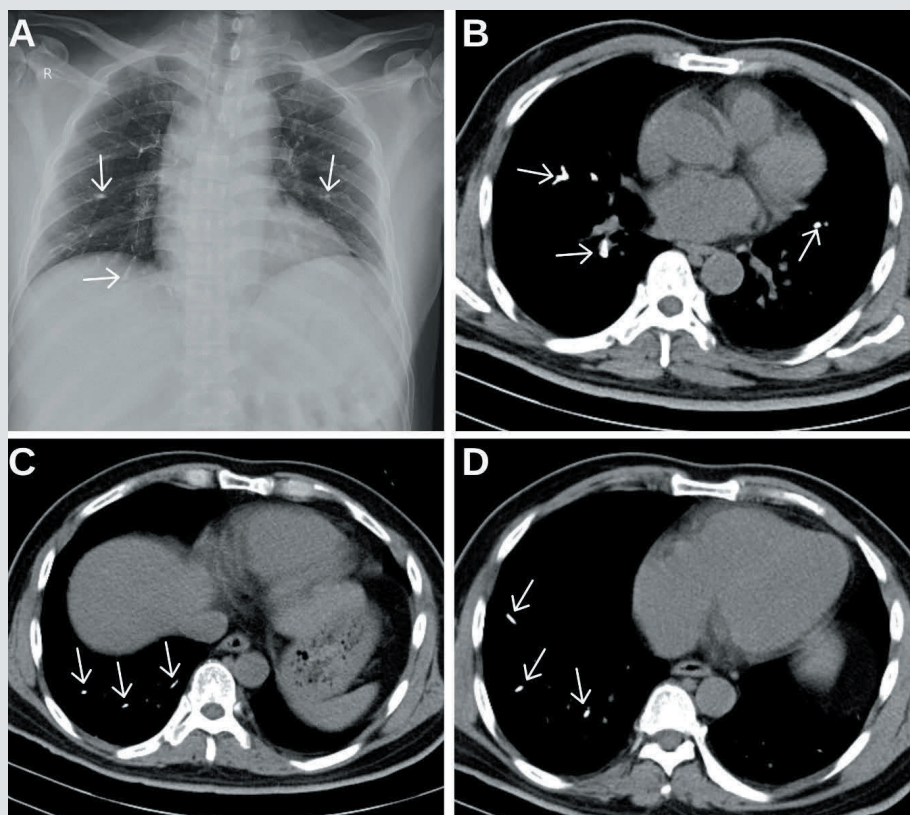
(A) Chest radiograph demonstrates multiple linear and nodular hyperdense opacities distributed along the pulmonary vasculature, predominantly on the right side (arrows). (B–D) Axial CT images of the chest reveal increased nodular and linear hyperdensities along the pulmonary vascular branches in the basal regions of both lungs, with right-sided predominance, consistent with pulmonary cement embolism (arrows).
